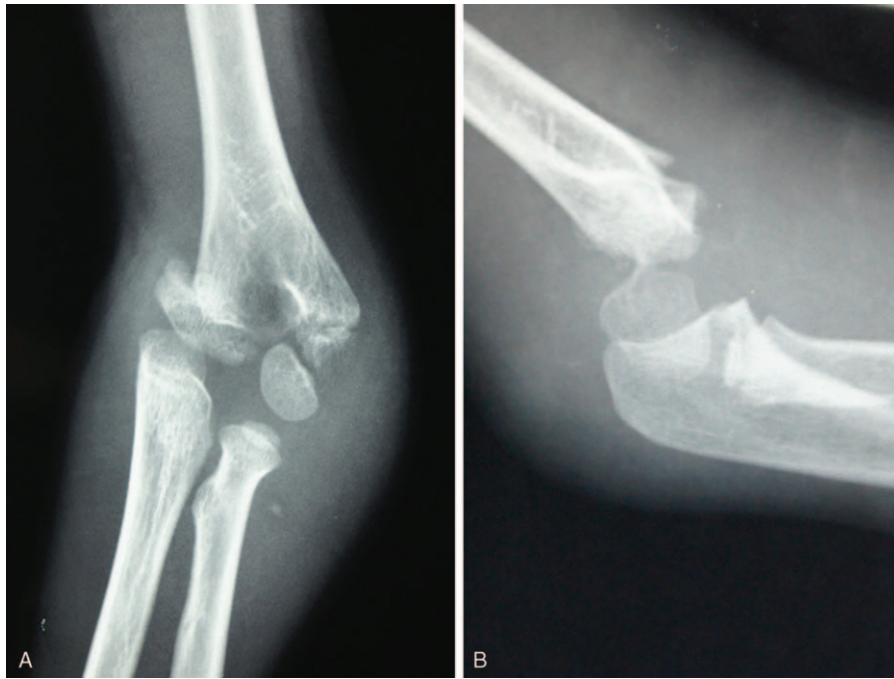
(A, B) Preoperative anteroposterior and lateral radiographs of the left elbow revealing a displaced intercondylar fracture.
